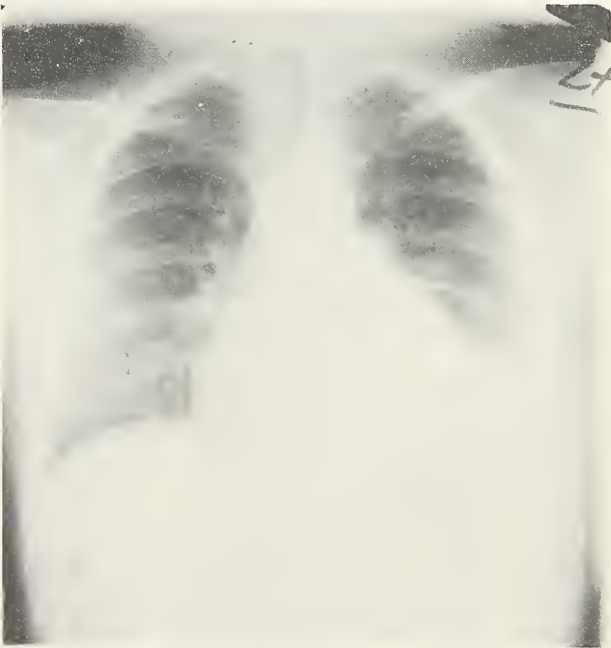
Chest roentgenogram in Case # 1 showing pericardial and bilateral pleural effusions.
